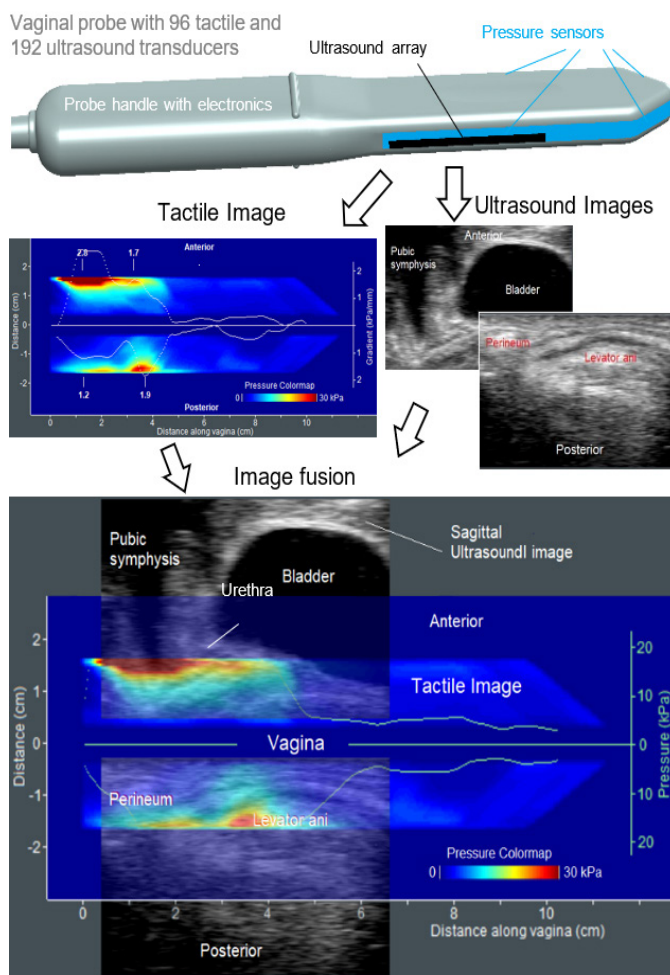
Tactile and ultrasound image fusion for test 1 (probe insertion) allows identification of pelvic anatomical landmarks and elasticity assessment for critical structures; 34 y.o. women with normal pelvic conditions [adapted from (88)]
